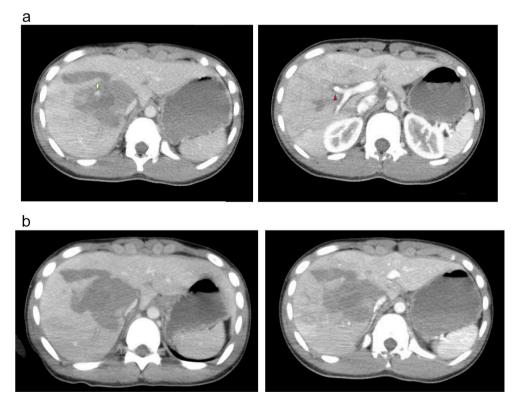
Findings of computed tomography scan on the day of injury.
